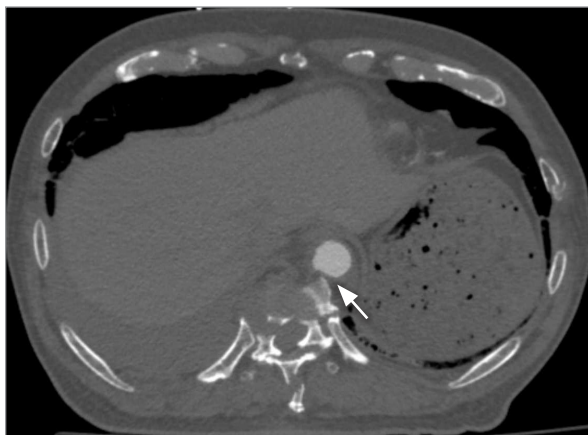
Axial computed tomography demonstrates a sharp fracture fragment of the ninth thoracic vertebra in close proximity to and appearing to compress the descending aorta (arrow).
